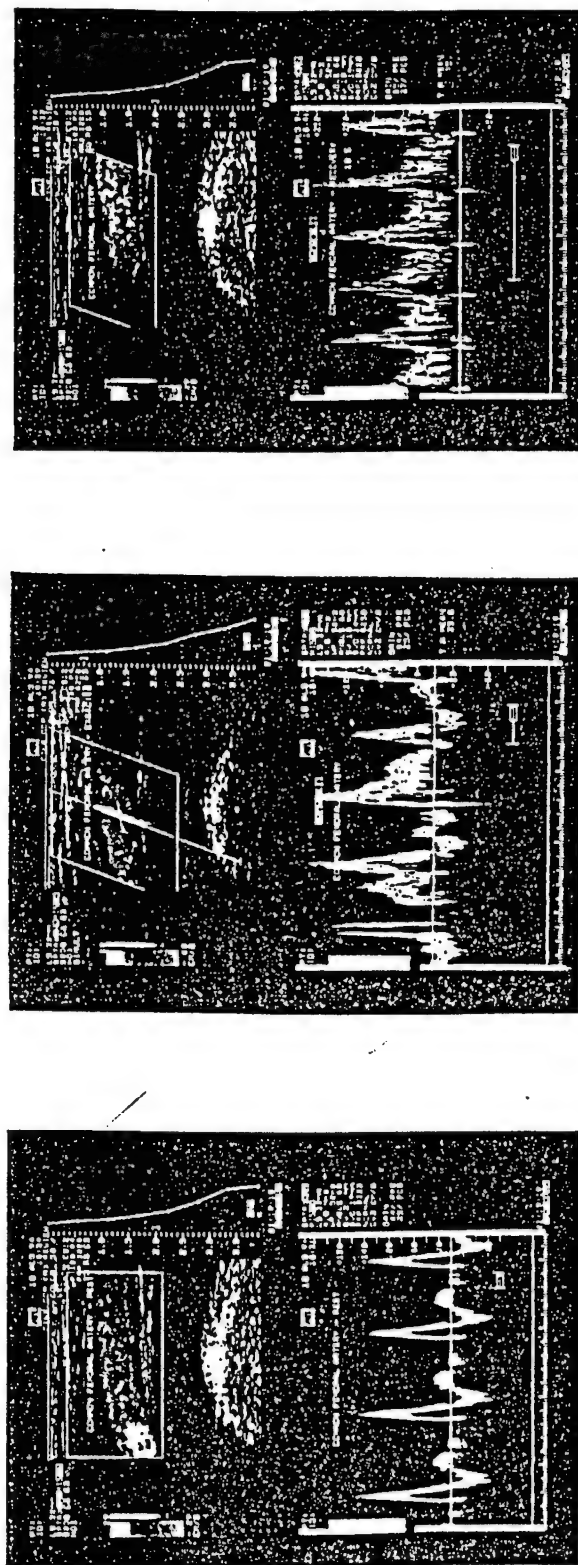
Blood flow velocity profiles and vessel dimensions of the common femoral artery for a normal subject at rest (*left*), during rhythmic quadriceps extensions (*centre*) and during recovery (*right*). Note that the oscillations during the exercise reflect both cardiac and skeletal muscle contractions. The white bar is an example of the Doppler "gate".
